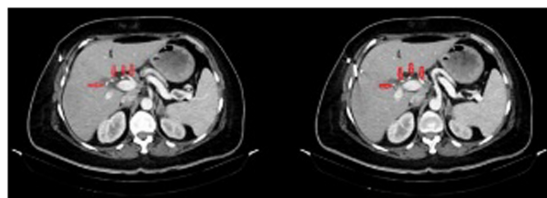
Intravenous contrast-enhanced computed tomography shows the right hepatic artery.
